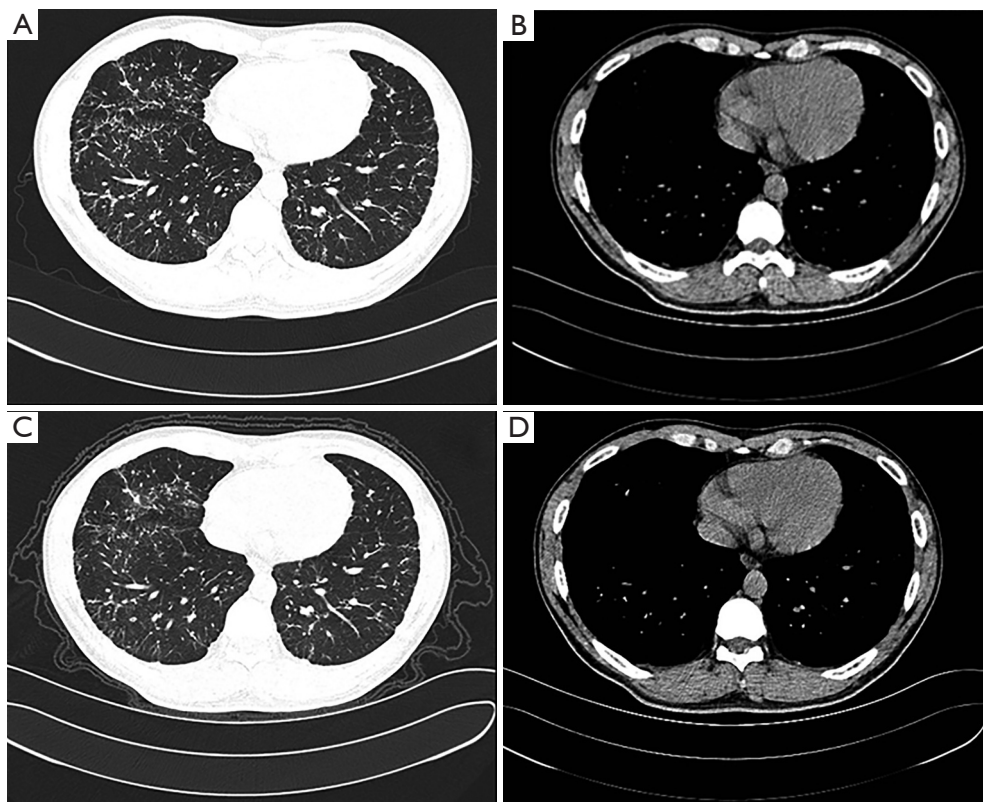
High-resolution computed tomography (HRCT) images of the proband. Lung windows and mediastinal windows of HRCT images of the chest showing there is no apparent progression of lung lesions over 2 years. (A,B) CT images of 2015-05-12; (C,D) images of 2017-07-12.
